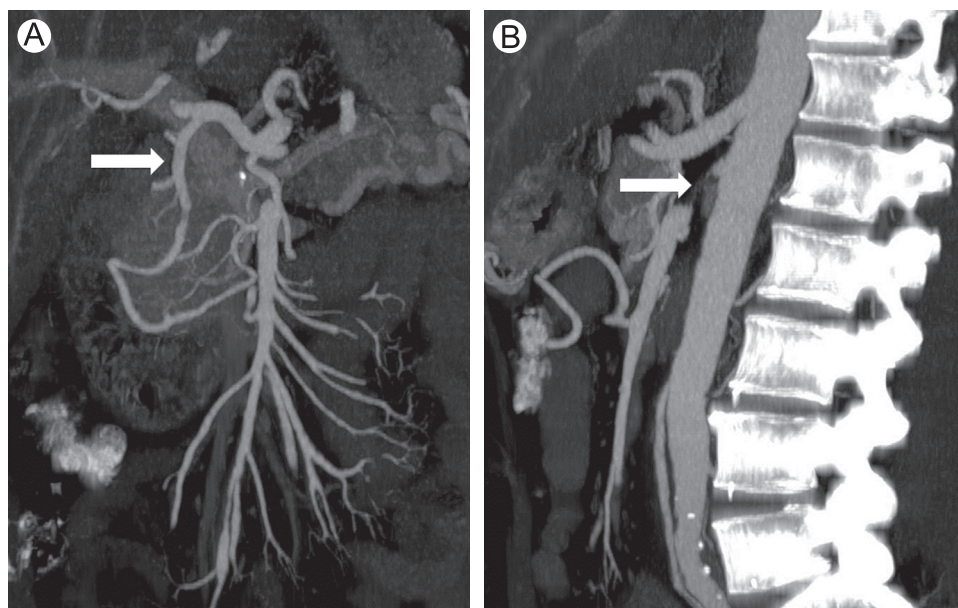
A 64-year-old patient with symptoms of weight loss, abdominal pain with eating, and food fear. (A) Maximum intensity projection (MIP) reconstruction of a CTA in a coronal plane shows dilation of the GDA and pancreaticoduodenal arcade (arrow), concerning for SMA ostial narrowing. (B) Sagittal plane image demonstrates short-segment occlusion of the SMA (arrow). GDA, gastroduodenal artery.
